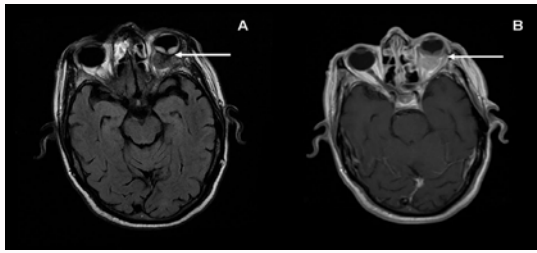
Transaxial magnetic resonance image showing a homogenous and well-defined intraconal mass lesion in the left orbit (arrows): isointense on T1 sequences (A) and hyperintense on T2 sequences (B).
